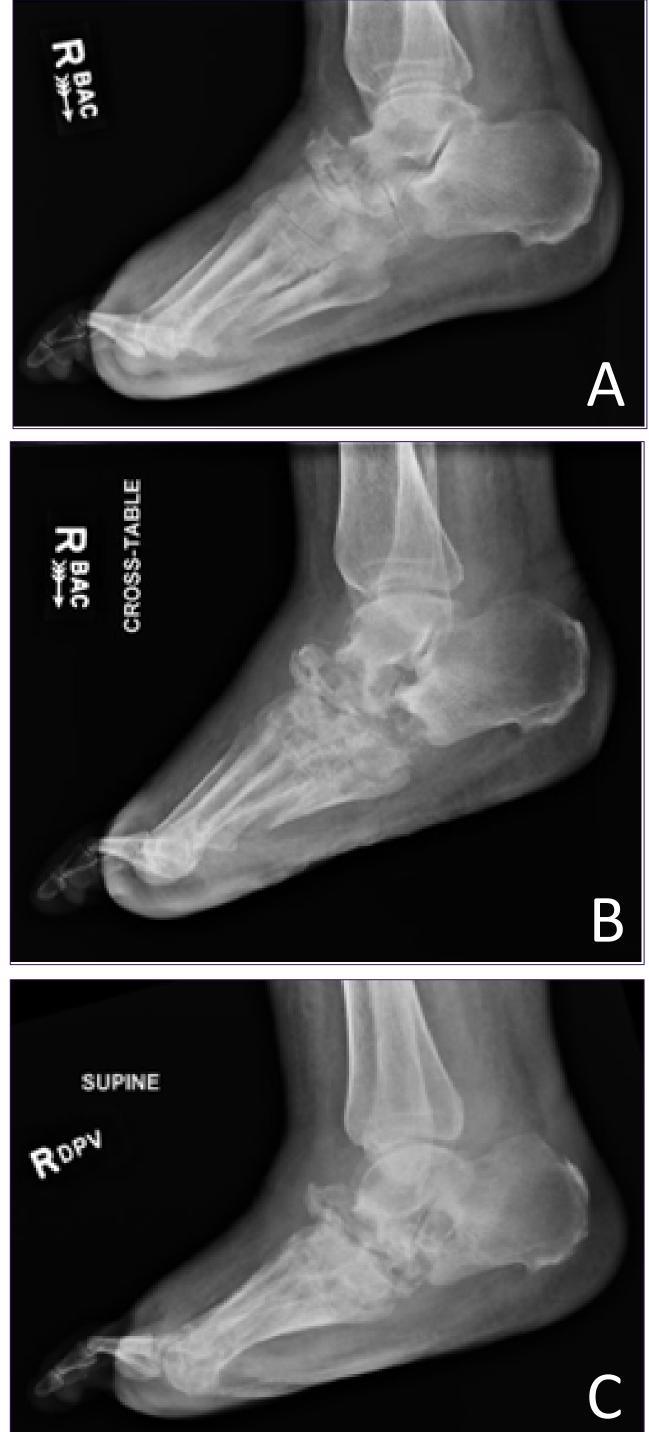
Radiographs taken upon subsequent patient visits, showing further destruction of the midtarsal joints. All images show the affected foot in a lateral projection. Panel A was taken on 5/6/21. Panel B was taken on 7/8/21. Panel C was taken on 9/29/21.
